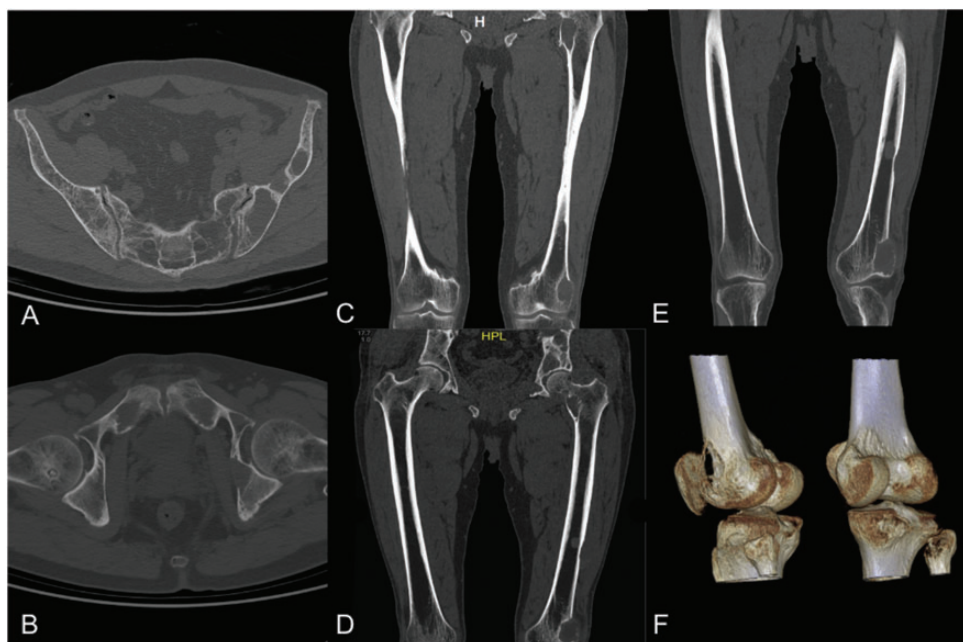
Three-dimensional reconstruction of computed tomography imaging of bilateral hips, femurs, and knees. Axial position (a–b), coronal multiplanar reconstruction (c–e), and volume reconstruction (f) of the bilateral hips, femurs, and knees.
